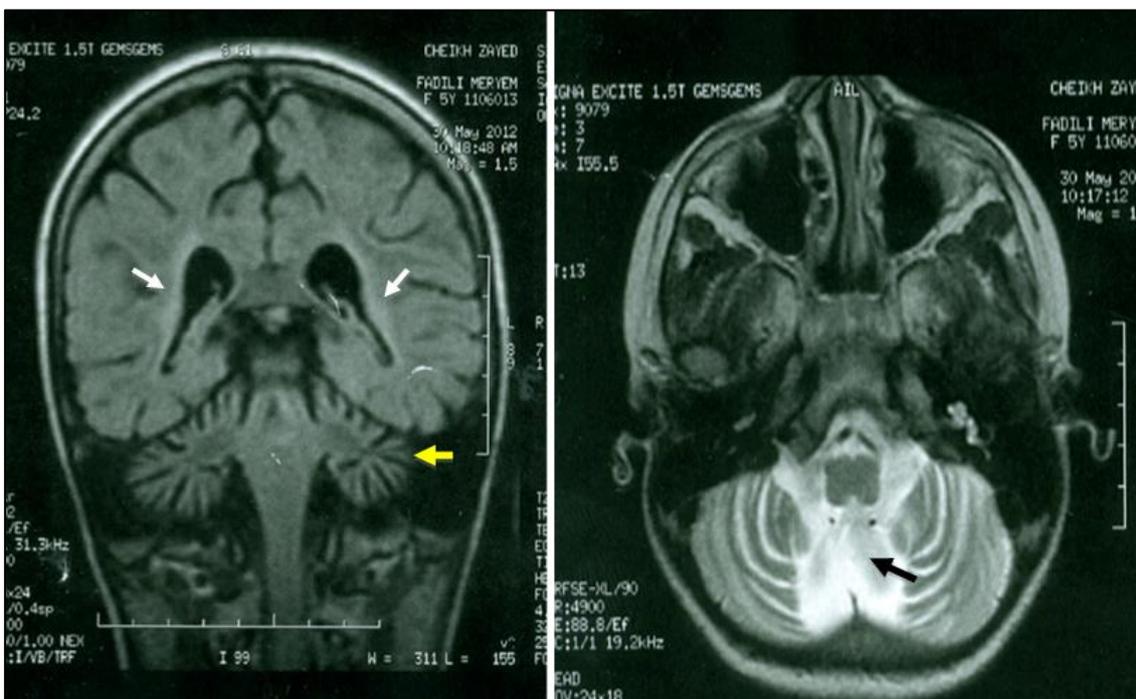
Cerebral MRI in coronal section shows signs of hemispheric cortical atrophy with widening of the cortical sulci, vermian and hemispheric cerebellar atrophy (yellow arrow) with mega-large cistern appearance (black arrow) and T2 hypersignal of the periventricular white matter (white arrows).
